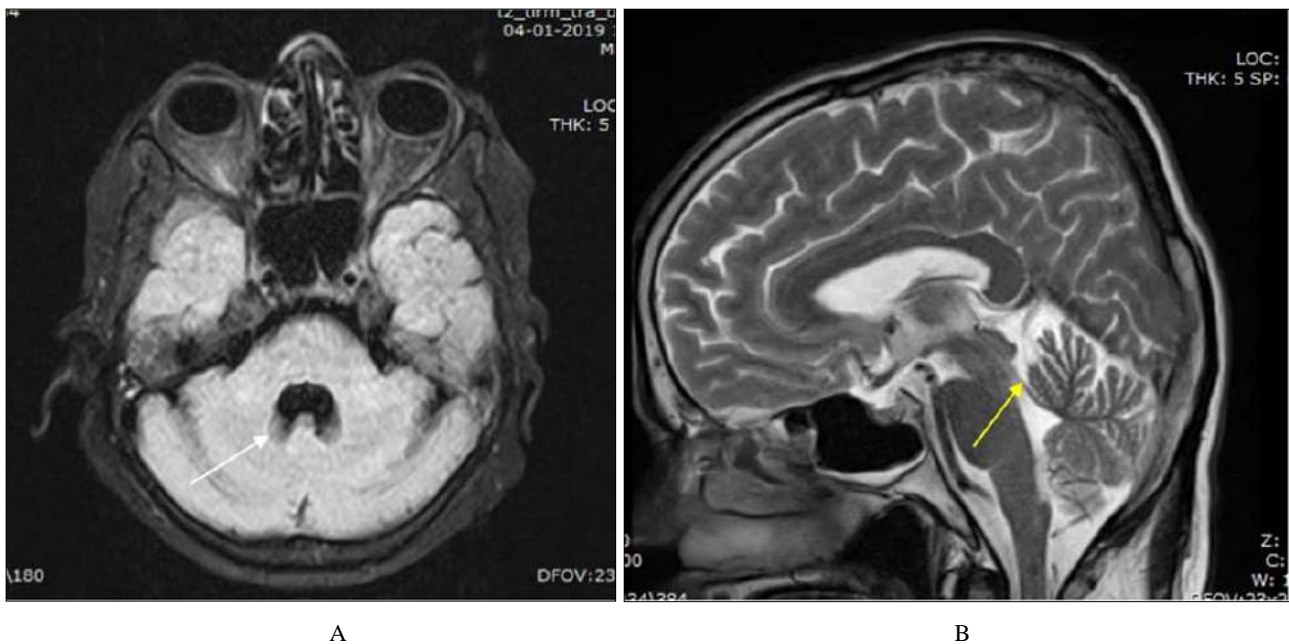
Axial sections of the brain A. T2 weighted image, B. FLAIR image, shows T2/FLAIR hyperintensities (yellow arrow) noted in pons and middle cerebellar peduncle sparing peripheral pons with no contrast enhancement on post contrast study (white arrow)
